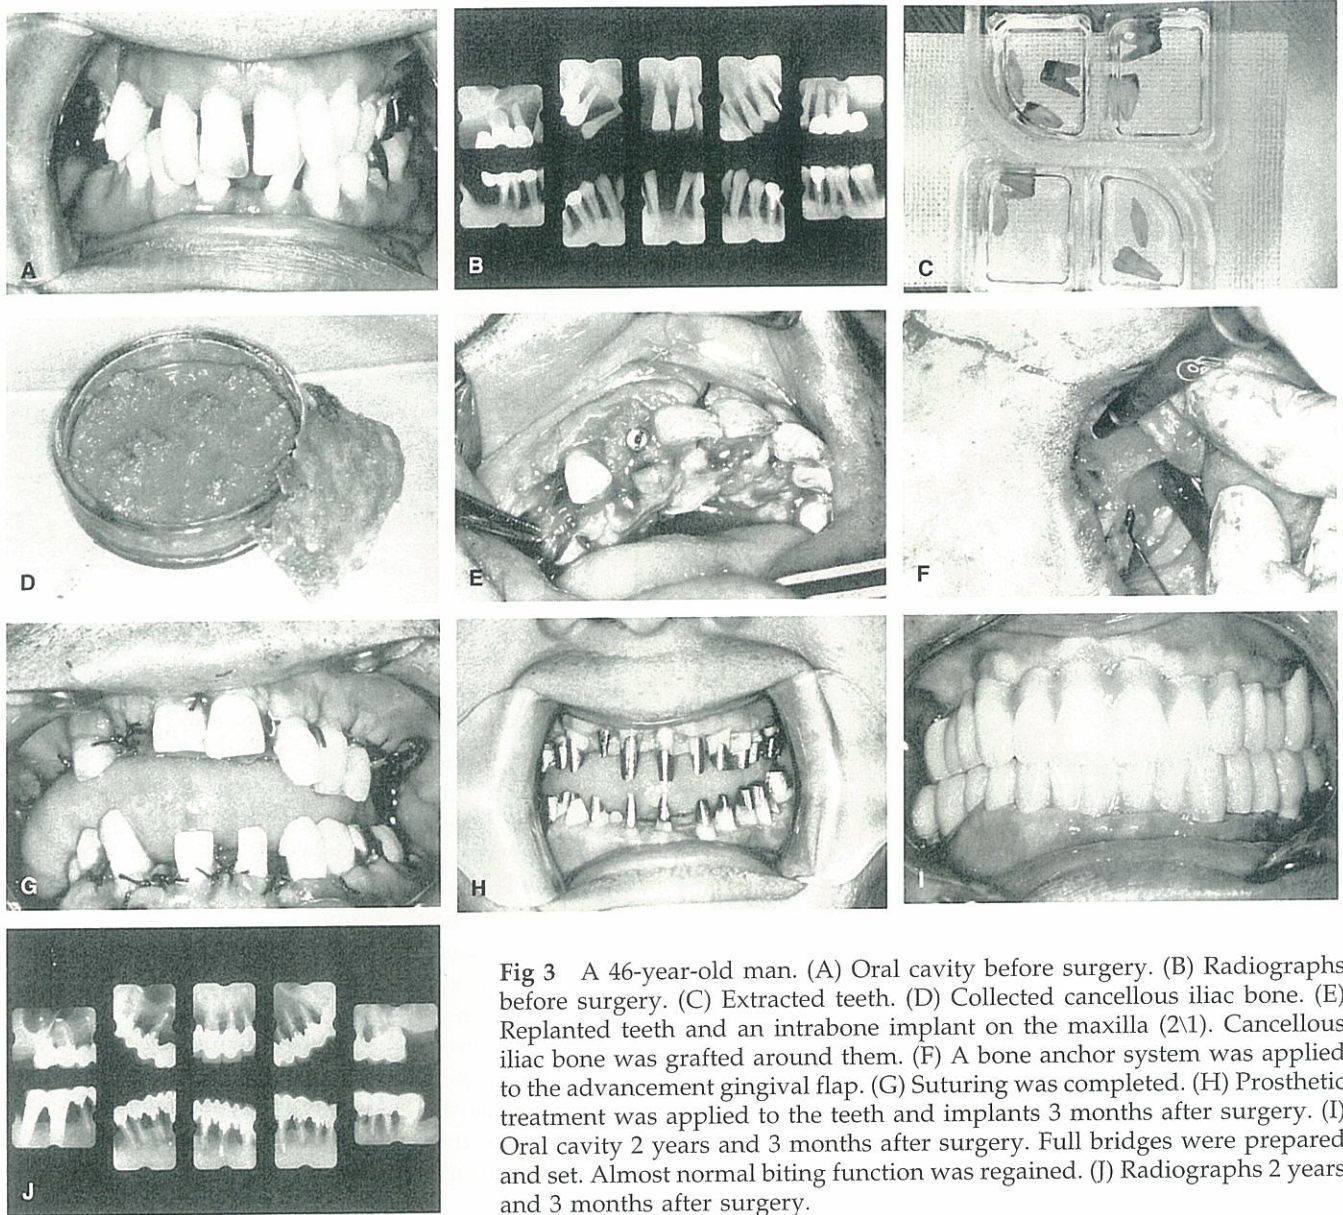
A 46-year-old man. (A) Oral cavity before surgery. (B) Radiographs before surgery. (C) Extracted teeth. (D) Collected cancellous iliac bone. (E) Replanted teeth and an intrabone implant on the maxilla (2/1). Cancellous iliac bone was grafted around them. (F) A bone anchor system was applied to the advancement gingival flap. (G) Suturing was completed. (H) Prosthetic treatment was applied to the teeth and implants 3 months after surgery. (I) Oral cavity 2 years and 3 months after surgery. Full bridges were prepared and set. Almost normal biting function was regained. (J) Radiographs 2 years and 3 months after surgery.
